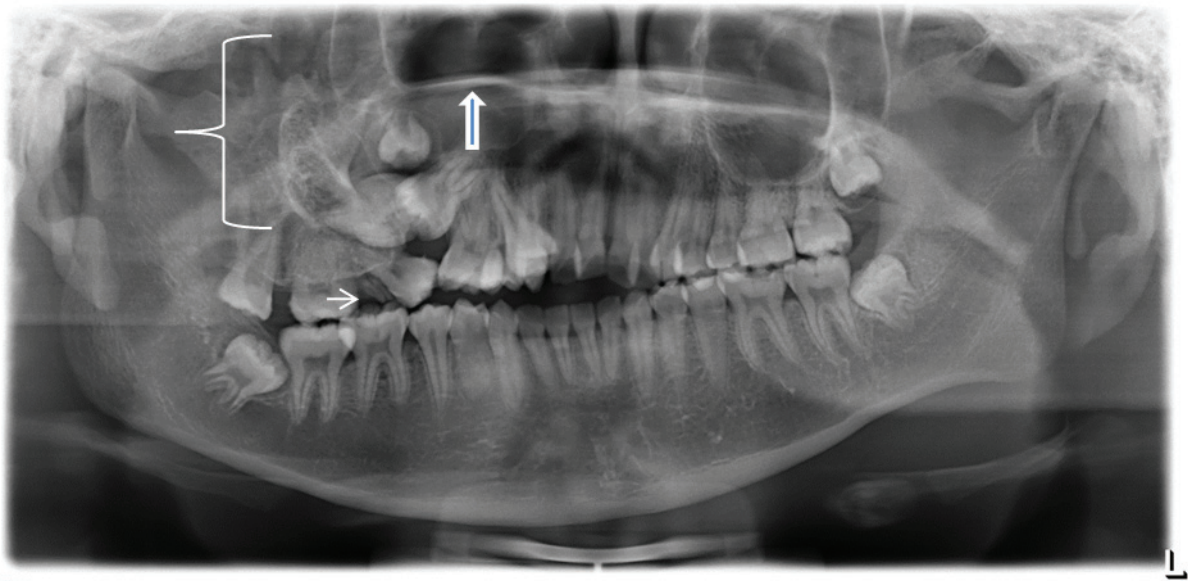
Panoramic radiograph showing double maxilla on the right side including supernumerary teeth and the deciduous retained root (arrow). The zygomatic process of the right maxilla showed a distorted shape and enlarged size (parenthesis). The right maxillary sinus was recessed. The right posterior hard palate was lifted (thick arrow). The lower border of the mandible on the right side was lower than that of the left side.
